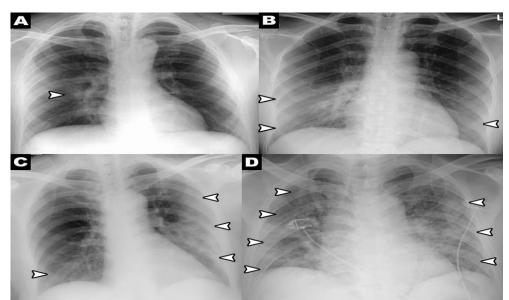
Chest radiograph scoring system. Consolidation or ground glass opacities (0, no involvement, 1.25%, 2.25%, -50%, 3.50%, -75%; and 4%, 0.75% involvement). Scores for each lung were collected to generate the final severity score. Below are examples of chest X-ray severity score and days from symptom onset in patients with 2019 coronavirus disease (calculation of right lung score + left lung score = total score used): A, day 12 (1 + 0 = 1); B, 5th day (2 + 1 = 3); C, day 3 (1 + 3 = 4); and D, day 10 (4 + 3 = 7). Arrowheads indicate areas of consolidation or ground glass.
